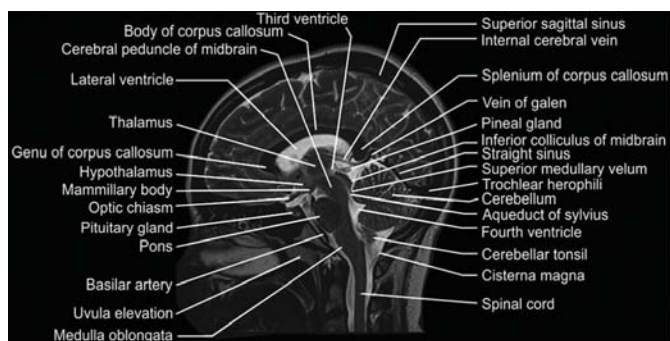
MRI Sagittal view of brain
